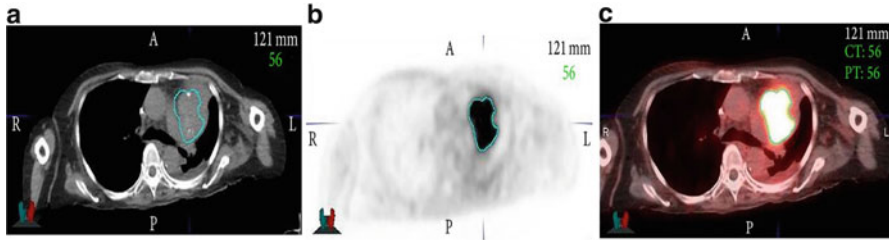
PET images differentiate neoplastic areas with hypermetabolic activity from within the surrounding normal tissue. (a) CT image, (b) PET image, and (c) fused PET/CT image. The teal color marks the gross tumor volume (GTV) as determined from PET image. *Modified and adapted with permission [18]*
